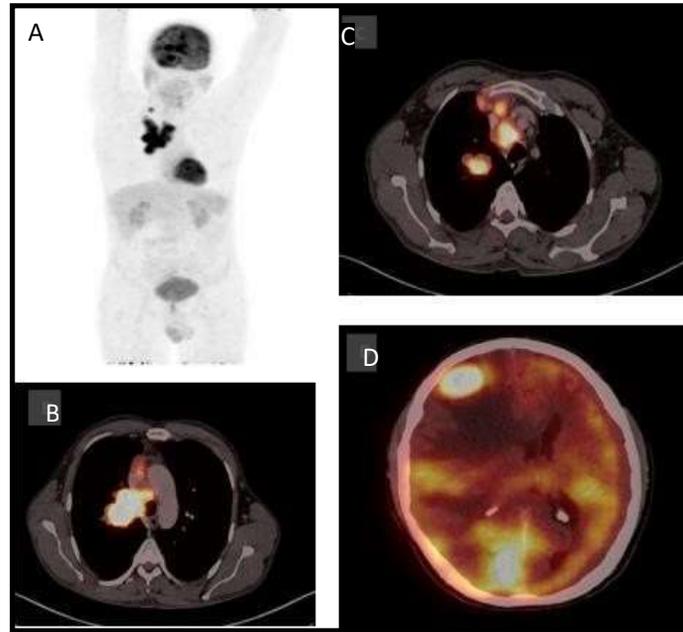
A- MIP image, B- Fusion image of 18F-FDG PET/CT in a 45 year old male with moderately differentiated lung adenocarcinoma of upper lobe of right lung, measuring 9.8 x 5.0 cms. SUV_{max}- 15.7, SUL_{peak}- 14.2, SUV_{mean}- 10.4, MTV- 51.3, TLG-534.8, with nodal and brain metastases (Stage IVB). C- Metabolically most active regional right upper paratracheal node and D- Distant brain metastasis in the right frontal lobe. The patient tested negative for both ALK and EGFR mutation.
